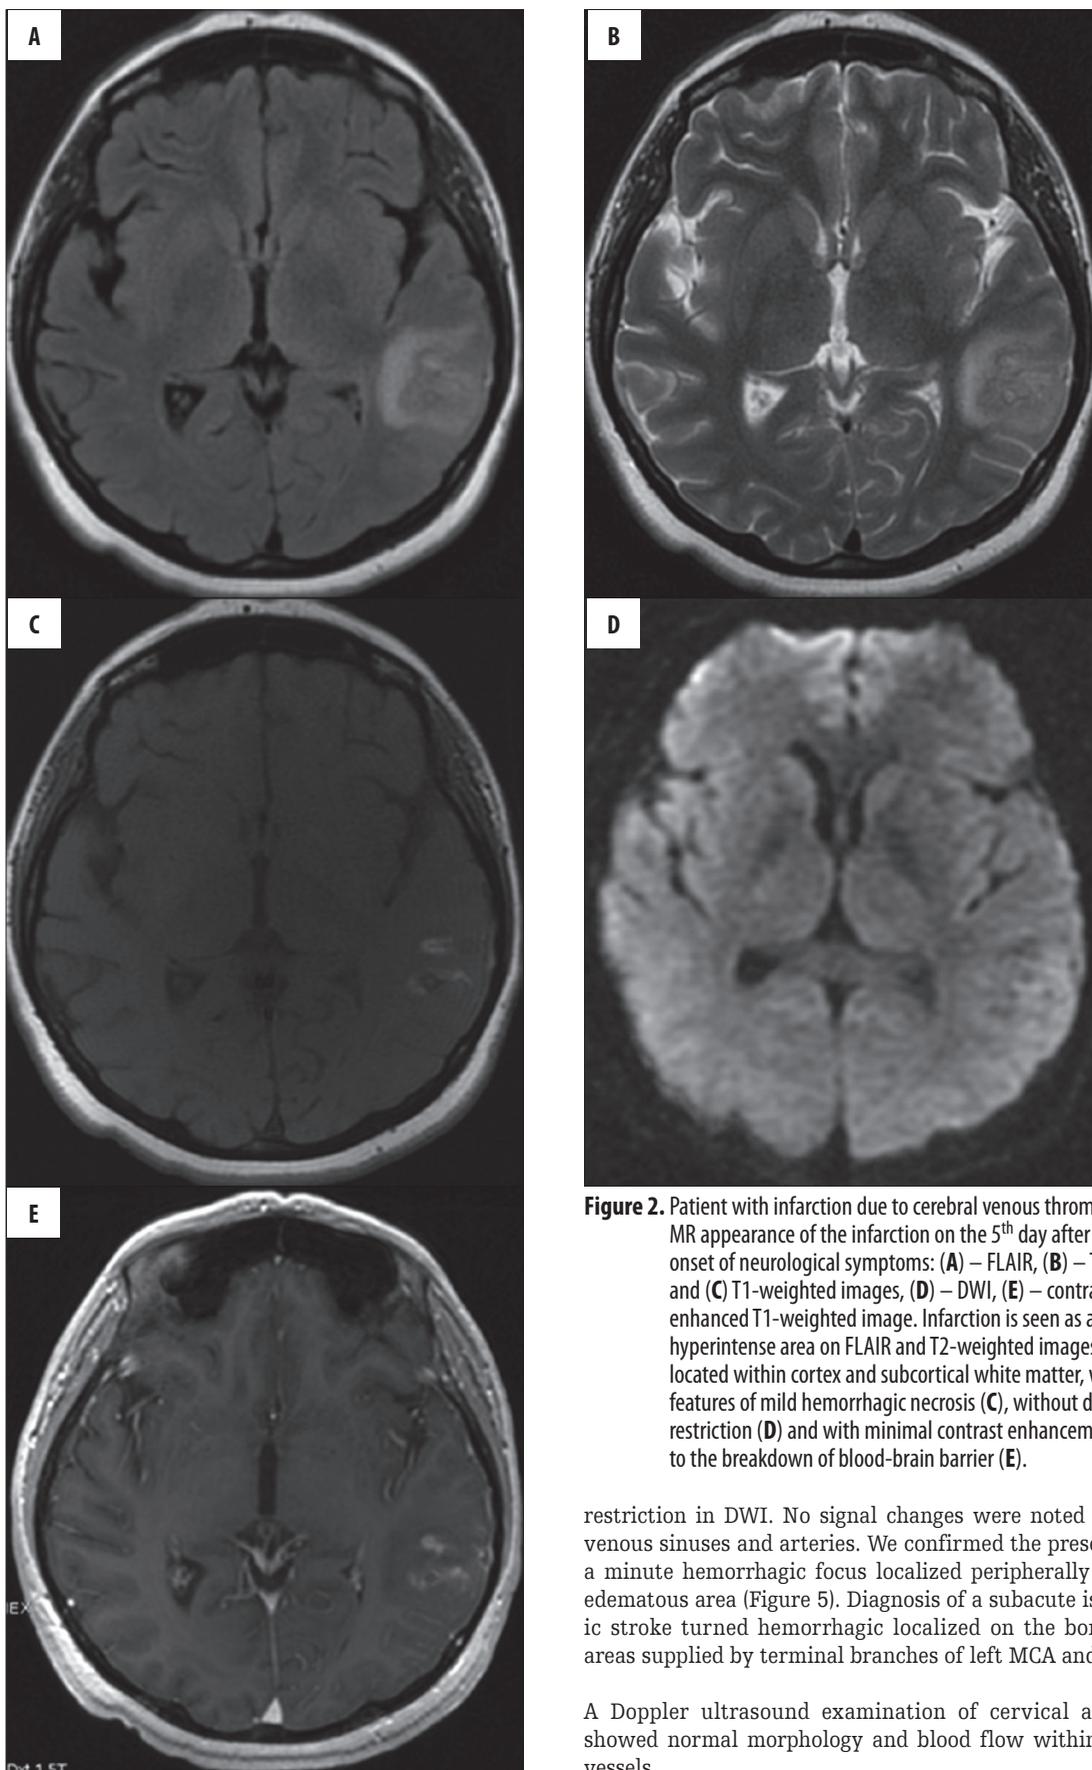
Patient with infarction due to cerebral venous thrombosis. MR appearance of the infarction on the 5th day after the onset of neurological symptoms: (A) – FLAIR, (B) – T2- and (C) T1-weighted images, (D) – DWI, (E) – contrast enhanced T1-weighted image. Infarction is seen as an hyperintense area on FLAIR and T2-weighted images located within cortex and subcortical white matter, with features of mild hemorrhagic necrosis (C), without diffusion restriction (D) and with minimal contrast enhancement due to the breakdown of blood-brain barrier (E).
